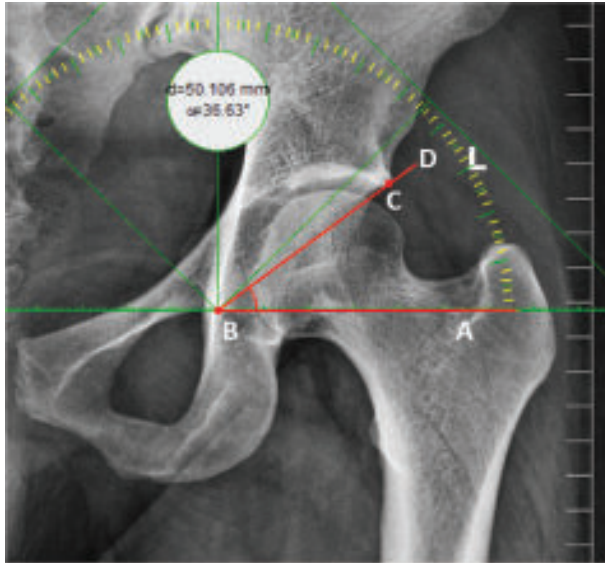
Plain digital radiograph of pelvis AP view showing measurement of Acetabular angle of Sharp
